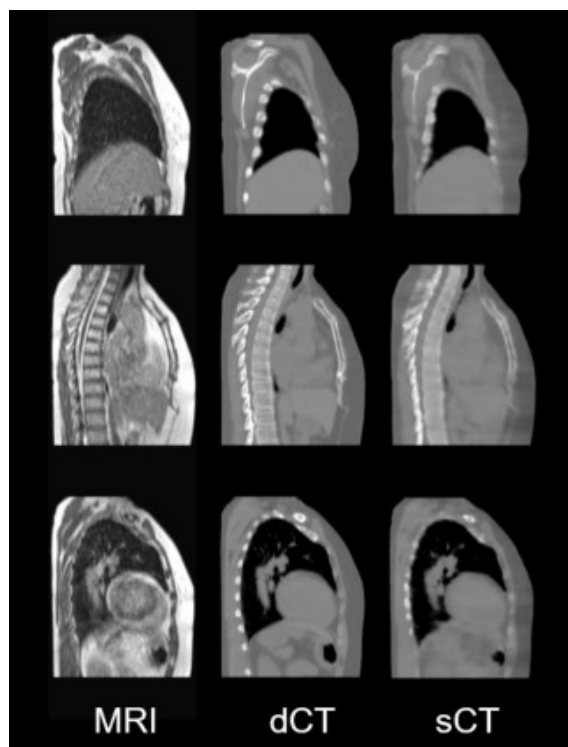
The representative sagittal slice views of MRI, dCT and sCT for thorax
